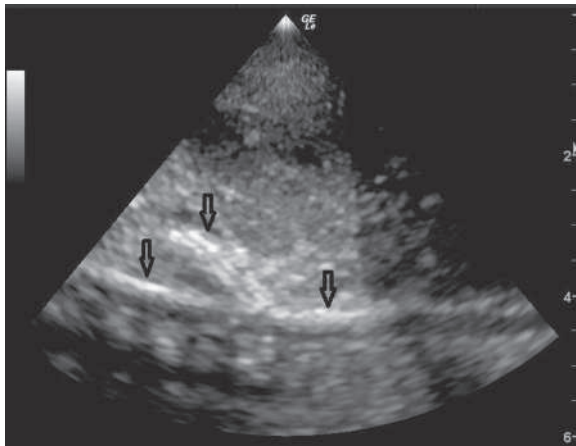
Ultrasonography of abdominal aorta showing calcification of descending aorta and its branches (arrows). (From Karthikeyan G. Generalized arterial calcification of infancy. *J Pediatr.* 2013;162:1074, Fig. 1.)
